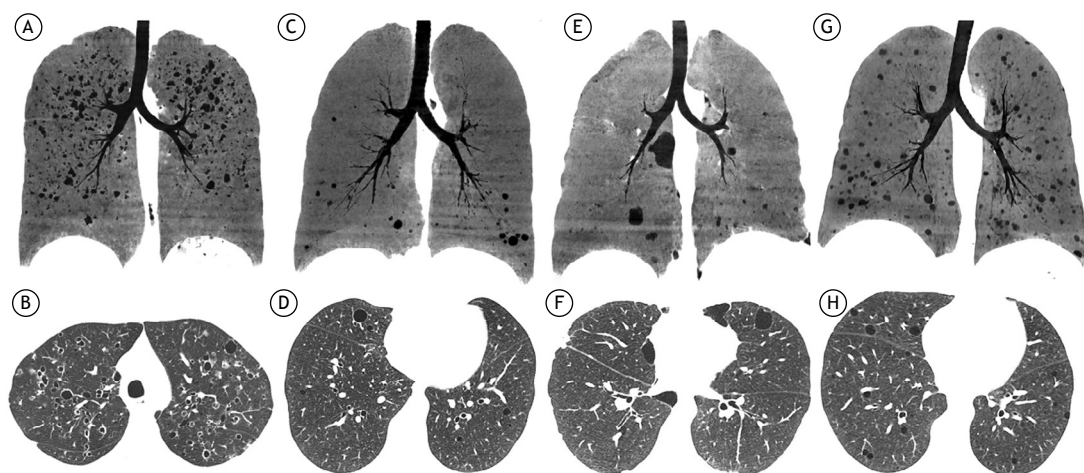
Differential diagnosis of lymphangioleiomyomatosis. Minimum-intensity projection reconstructions of coronal CT scans in A, C, E and G, and axial CT scans, with lung window settings, in B, D, F and H. In A and B, pulmonary Langerhans cell histiocytosis, with cysts of variable sizes/shapes and some small centrilobular nodules, predominantly in the upper lung fields. Note that the costophrenic recesses are preserved. In C and D, lymphocytic interstitial pneumonia, with some of the cysts having an axial distribution, mainly peribronchovascular, concentrated in the lung bases. In E and F, Birt-Hogg-Dubé syndrome, in which the cysts are typically larger and elliptical, usually with a paramediastinal distribution in the lower lung fields. In G and H, an unusual manifestation of constrictive bronchiolitis, with sparse, randomly distributed cysts.
